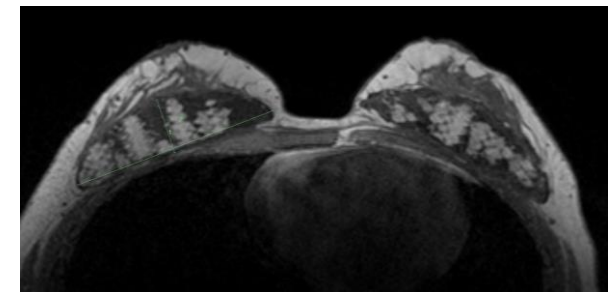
MRI of PCL scaffold with 50% autologous fat graft 2-month post-surgery
